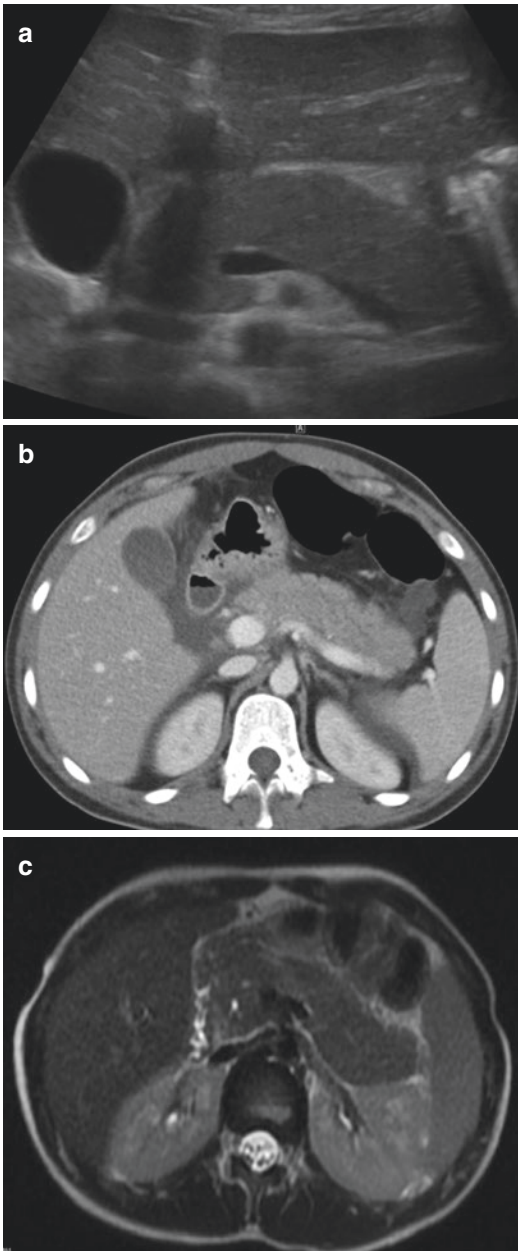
Acute pancreatitis—Classic appearance on imaging of the pancreatic gland after the first days of edematous acute pancreatitis in different patients. (a) US transverse scan showing an enlarged pancreatic gland with convex contours. (b) CE-CT showing a swollen homogenous pancreatic gland with convex contours. Some effusion is visible. (c) MR imaging T2-weighted sequence showing an enlarged pancreatic gland with convex contours
